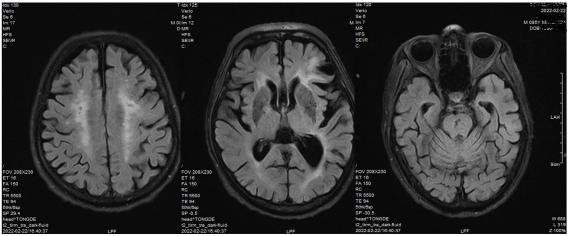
Magnetic resonance image of the brain showing multiple chronic lacunar infarcts
